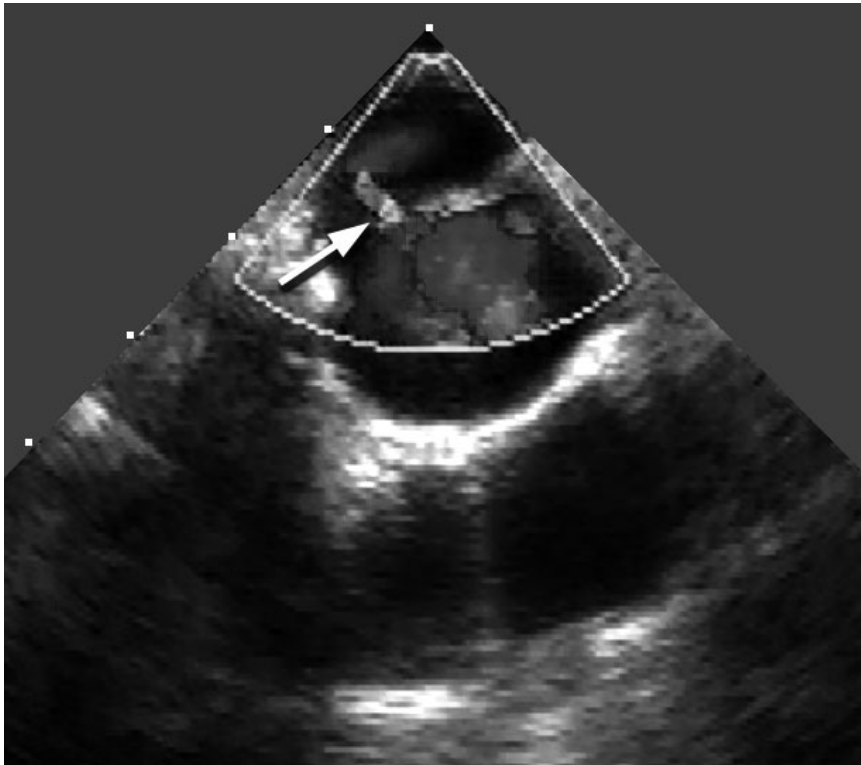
Transesophageal echocardiographic cross-sectional image in the short-axis with color flow Doppler depicting transection of the aortic isthmus. The transection appears as two distinct lumens, the “double-barrel” sign, and there is flow between the separated aorta. (Courtesy of B. Milas, University of Pennsylvania.)
